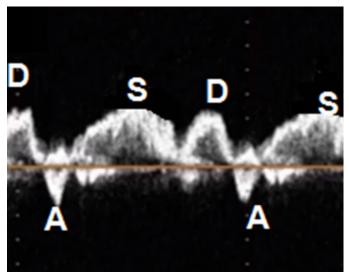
Transesophageal echocardiography. Midesophageal view at 75 degrees. Pulsed Doppler at the level of LSPV shows the presence of 3 waves: S, D and A.
